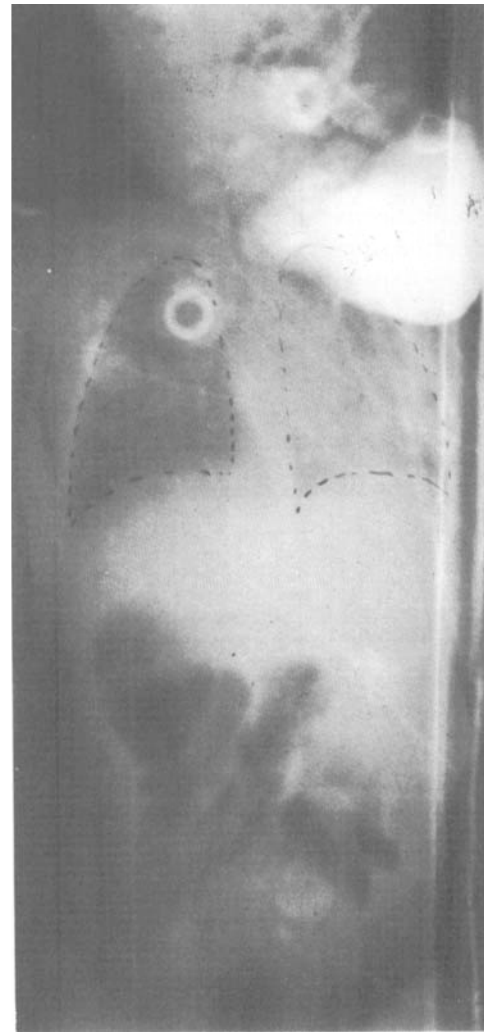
A portal film used in connection with a total body irradiation using 4 MV x-rays. The film is used to determine the position of the lung shield.
